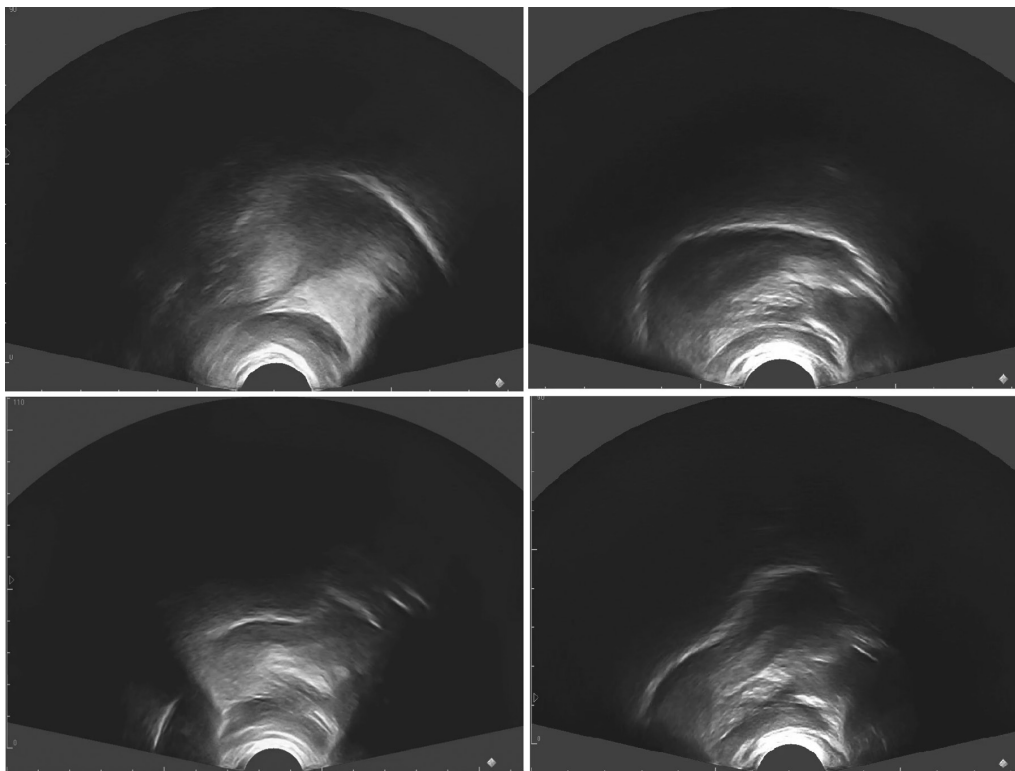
Distorted (top row) and correct (bottom row) tongue shapes for /ɪ/ with ultrasound imaging.
